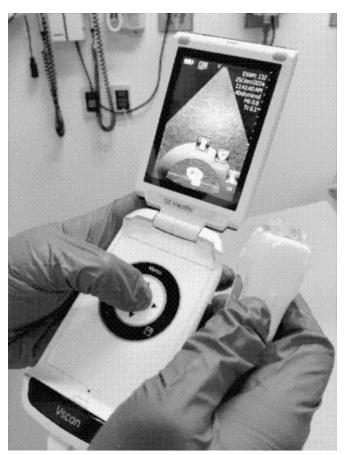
General Electric Vscan Pocket Ultrasound.
